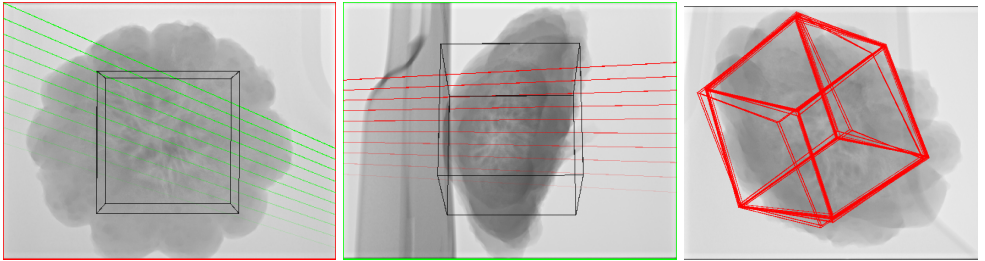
Left, Center: reference images (X-ray intensity before logarithm). Epipolar lines are shown in the color of corresponding frame. Right: Visualization of 25 iterations of a random study of $\pm 10^\circ$ and ± 25 mm showing two outliers.
